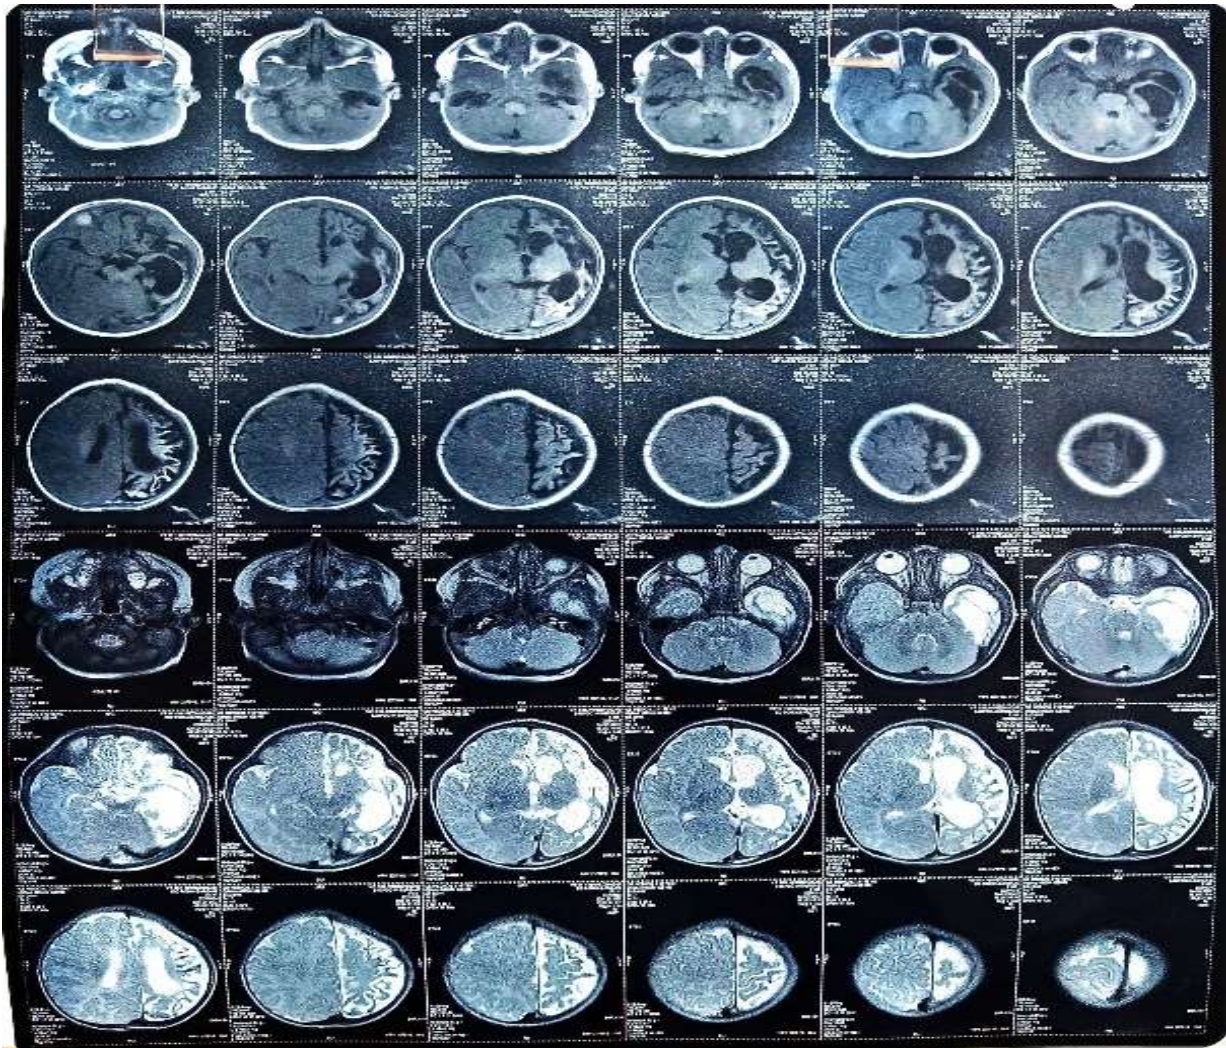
Gyriform sulci -tramtrack sign present in left lobe of brain on MRI
